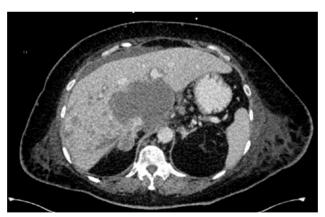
Computed tomography confirming cystic liver lesions
